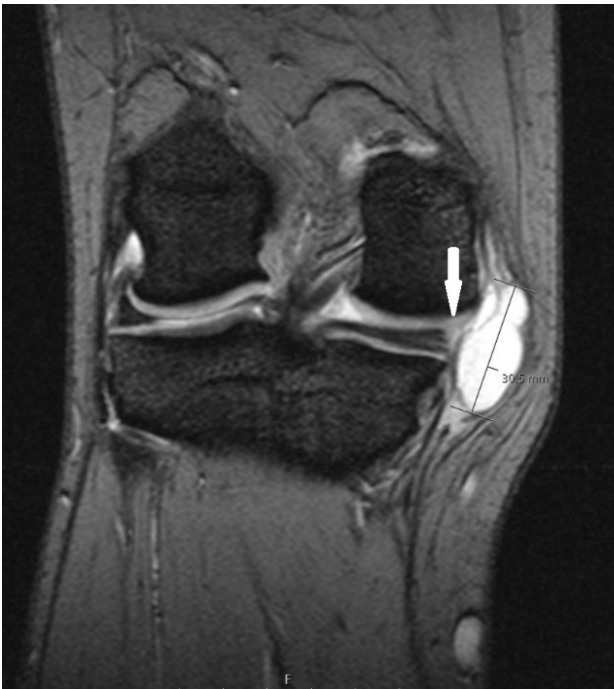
A T2* Multi-GRE MRI sequence showing an ovoid cystic lesion with 3.05cm in the longest axis, compatible with a parameniscal cyst.
